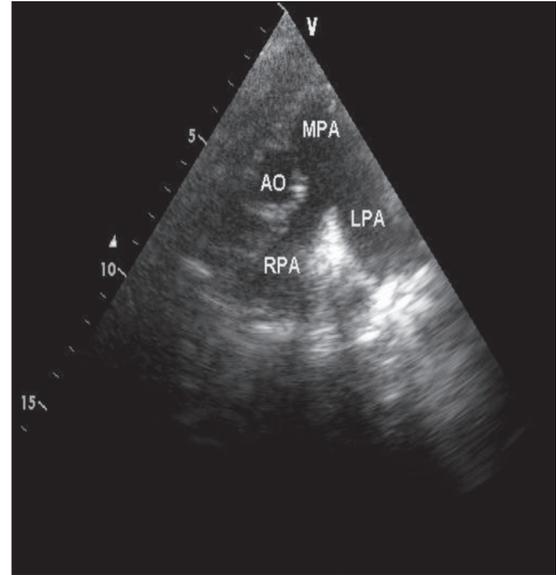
Transthoracic parasternal short-axis echocardiography view of a large thrombus in the main pulmonary artery bifurcation
